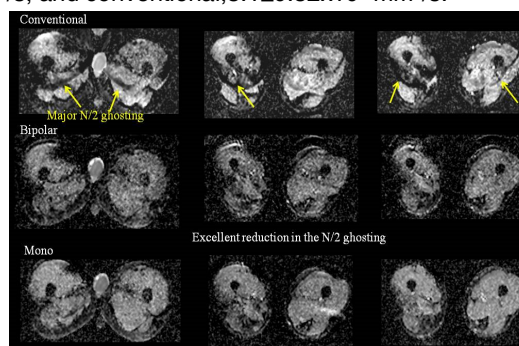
Examples of the DWI with ADC maps using three types of DWI sequences (monopolar and bipolar of advanced DWI and conventional bipolar DWI) in the thigh.
